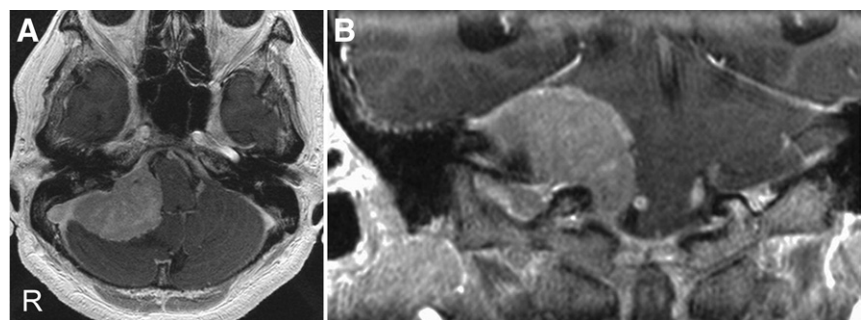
Axial (A) and coronal (B) views of magnetic resonance imaging (MRI) for posterior petrous type showed meningioma at the right cerebellopontine angle (CPA) attached to the posterior petrosal dura. The attachment was confirmed intraoperatively.
